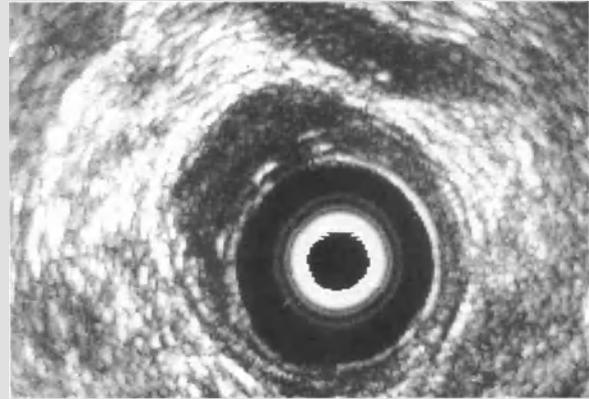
Endoluminal ultrasonography of the rectum with direct water coupling. The exam can be conducted with 5, 8, or 10 MHz scanning probes
